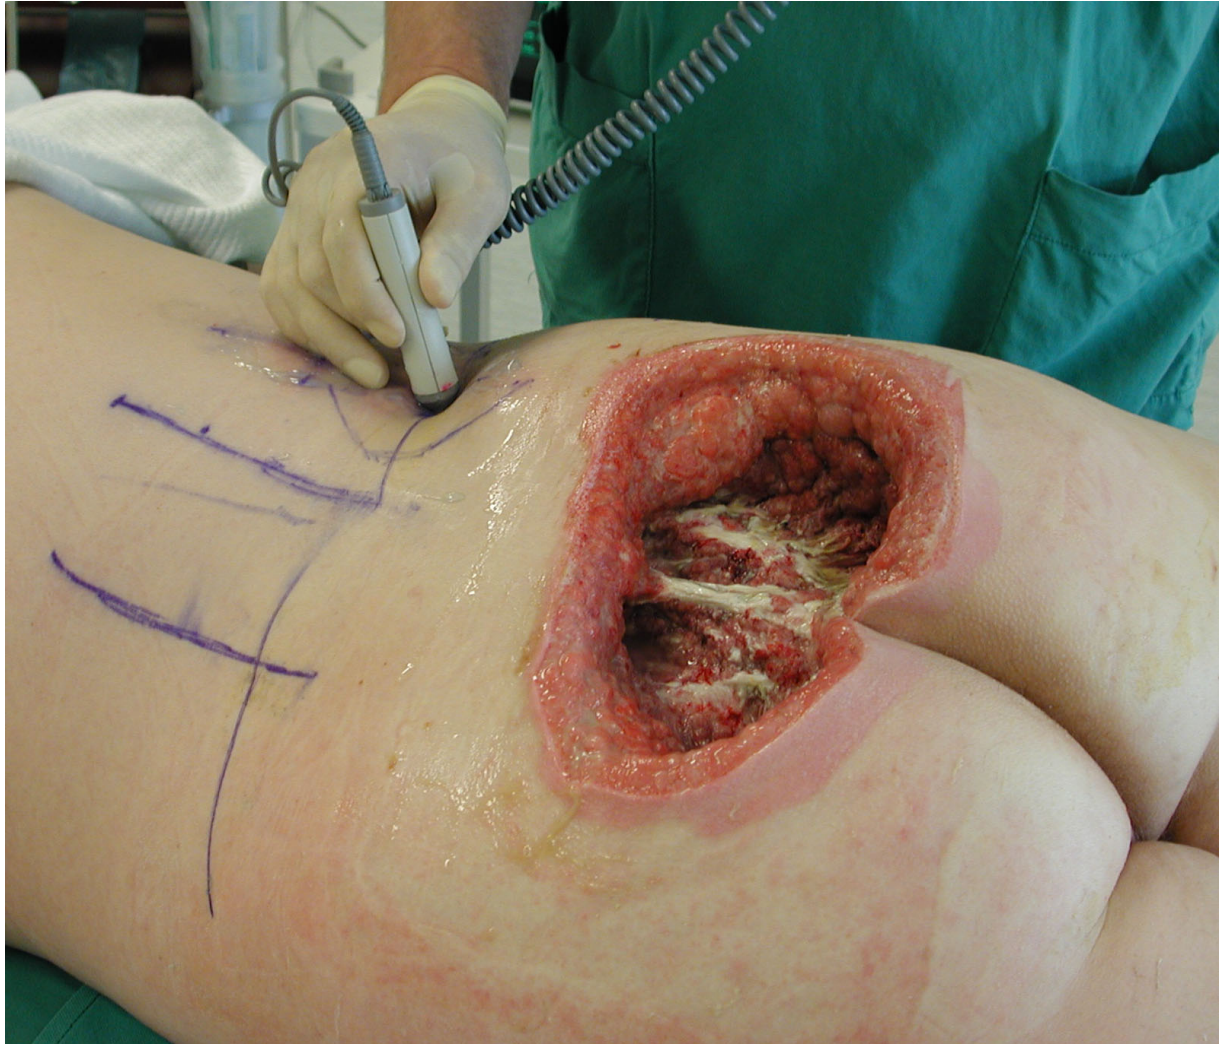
Hand-held Doppler is widely used in the evaluation of arterial perforators. This patient had a large pressure sore that was operated with *The Butterfly Design* using two flaps based on lumbar artery perforators [58].
